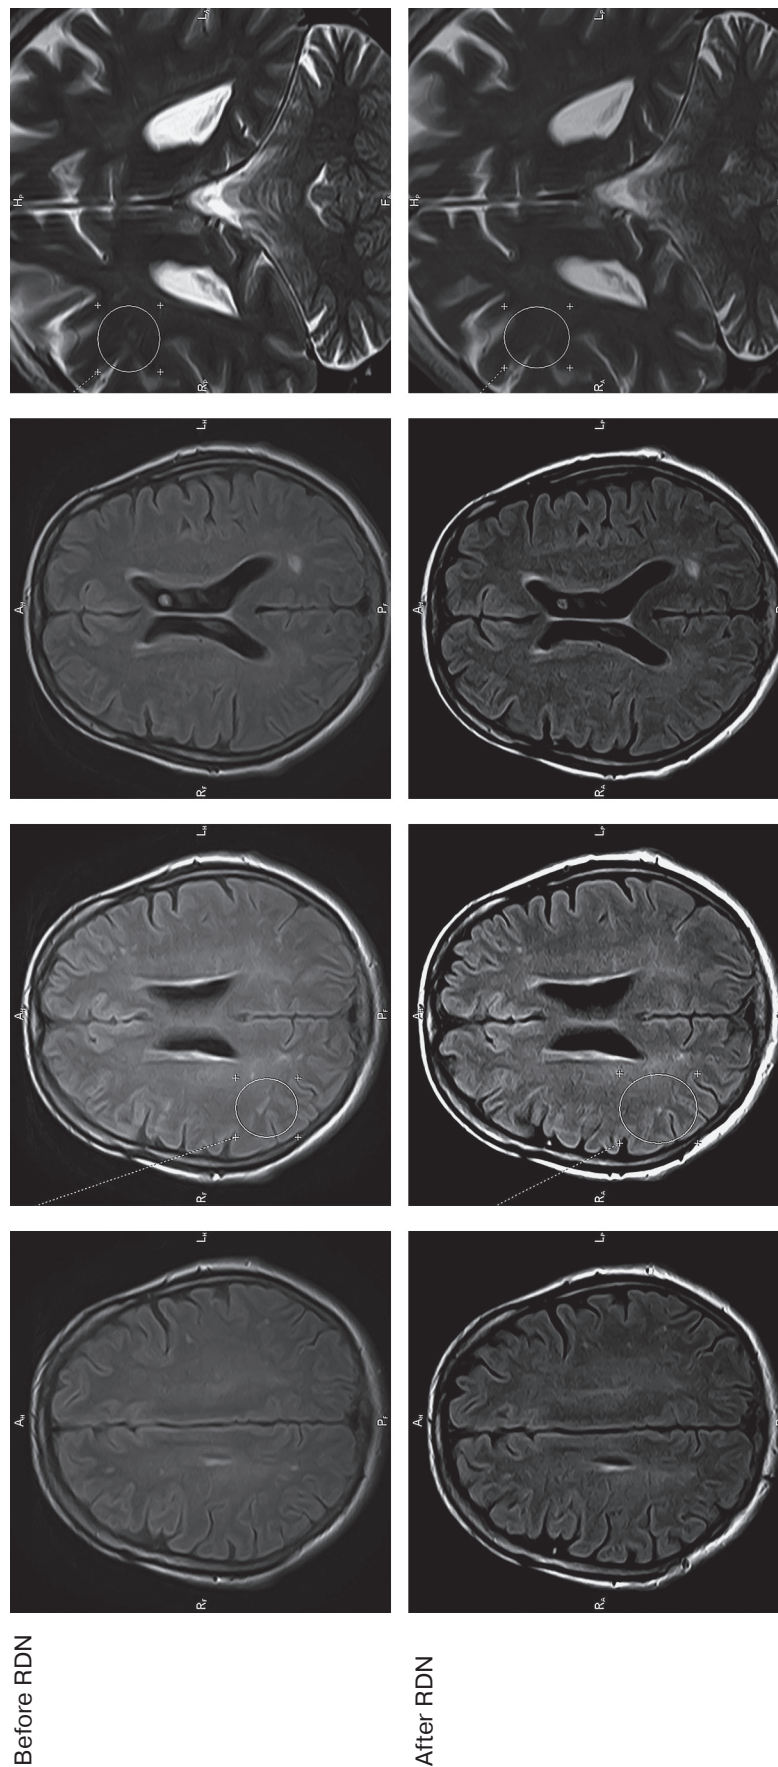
Changes in the MRI picture after the application of RFA.
